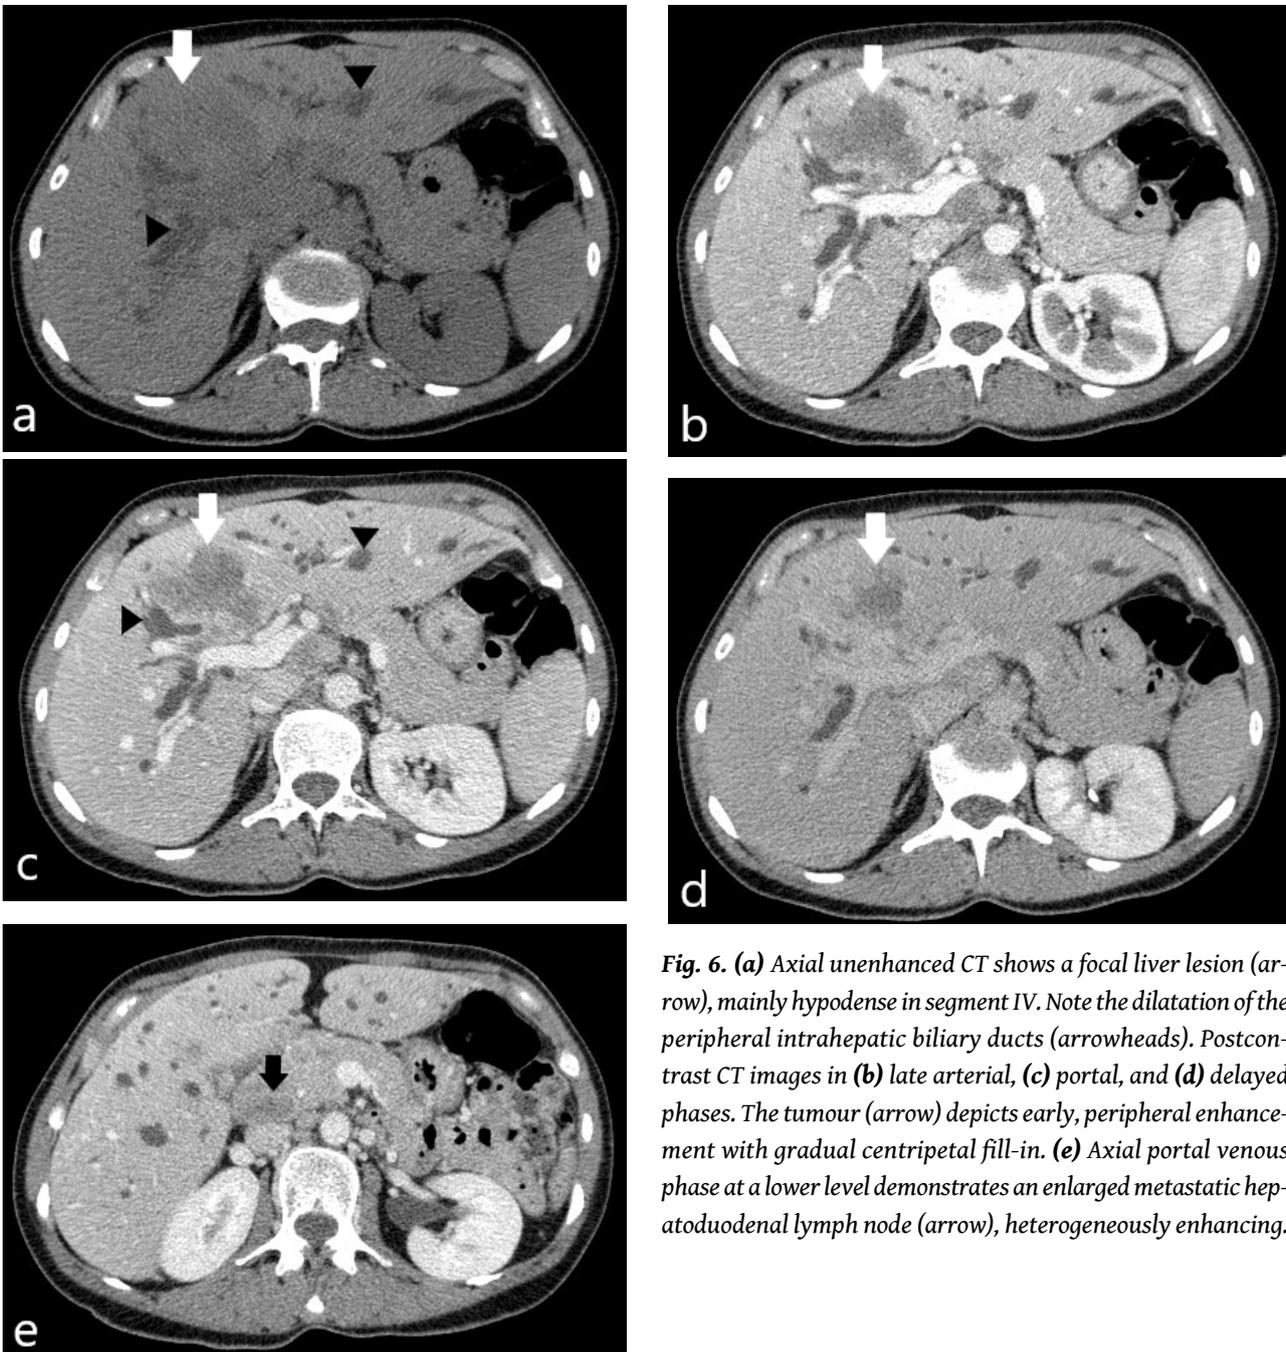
(a) Axial unenhanced CT shows a focal liver lesion (arrow), mainly hypodense in segment IV. Note the dilatation of the peripheral intrahepatic biliary ducts (arrowheads). Postcontrast CT images in (b) late arterial, (c) portal, and (d) delayed phases. The tumour (arrow) depicts early, peripheral enhancement with gradual centripetal fill-in. (e) Axial portal venous phase at a lower level demonstrates an enlarged metastatic hepatoduodenal lymph node (arrow), heterogeneously enhancing.
